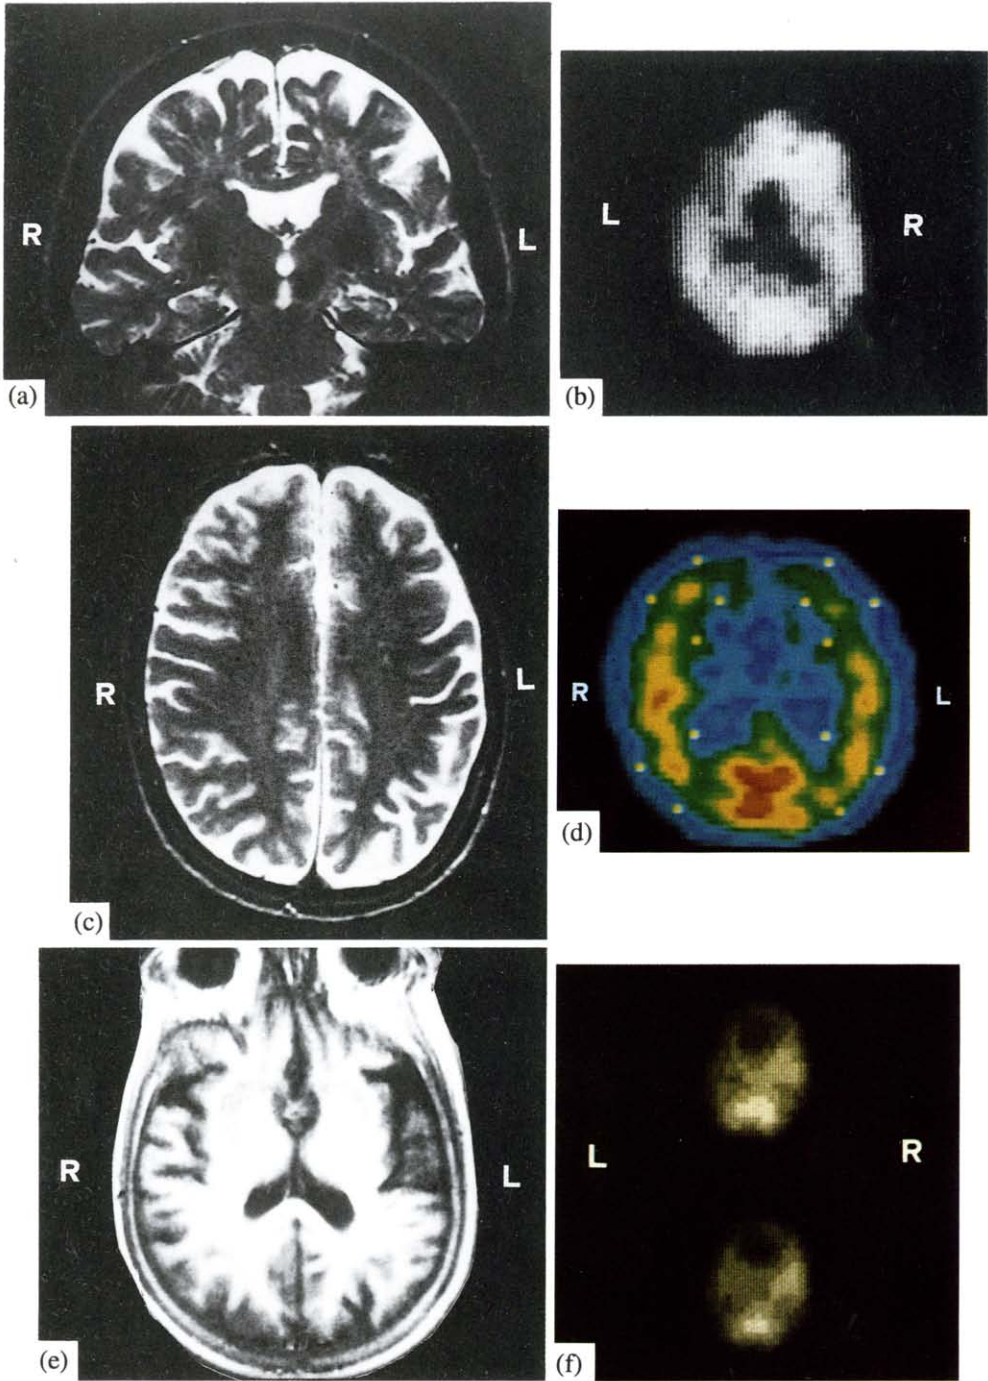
Neuroimaging findings. (a) Patient R.A.: coronal T2-weighted MRI (December 1988). Marked cortical atrophy of the posterior regions of the frontal lobes, mainly involving the medius and inferior frontal gyri of the left hemisphere. Small areas of increased signal intensity in the corona radiata frontalis. Enlargement of Virchow-Robin's spaces. (b) Patient R.A.: 99m Tc HM-PAO SPECT (February 1989). Reduction in rCBF restricted to the frontal regions of the left hemisphere (10% of interhemispheric asymmetry). (c) Patient G.G.: axial T2-weighted MRI (July 1991). Moderate atrophy of the posterior regions of the left frontal lobe. (d) Patient G.G.: 99m Tc HM-PAO SPECT (July 1991). Reduction in rCBF restricted to the frontal regions of the left hemisphere (14% of interhemispheric asymmetry). (e) Patient G.P.: axial T1-weighted MRI (December 1988). Striking cortical and subcortical atrophy of the left temporal lobe, more evident in the anterior temporal regions. (f) Patient G.P.: 99m Tc HM-PAO SPECT (January 1989). Marked reduction in rCBF in the temporal regions of the left hemisphere (39% of interhemispheric asymmetry).
